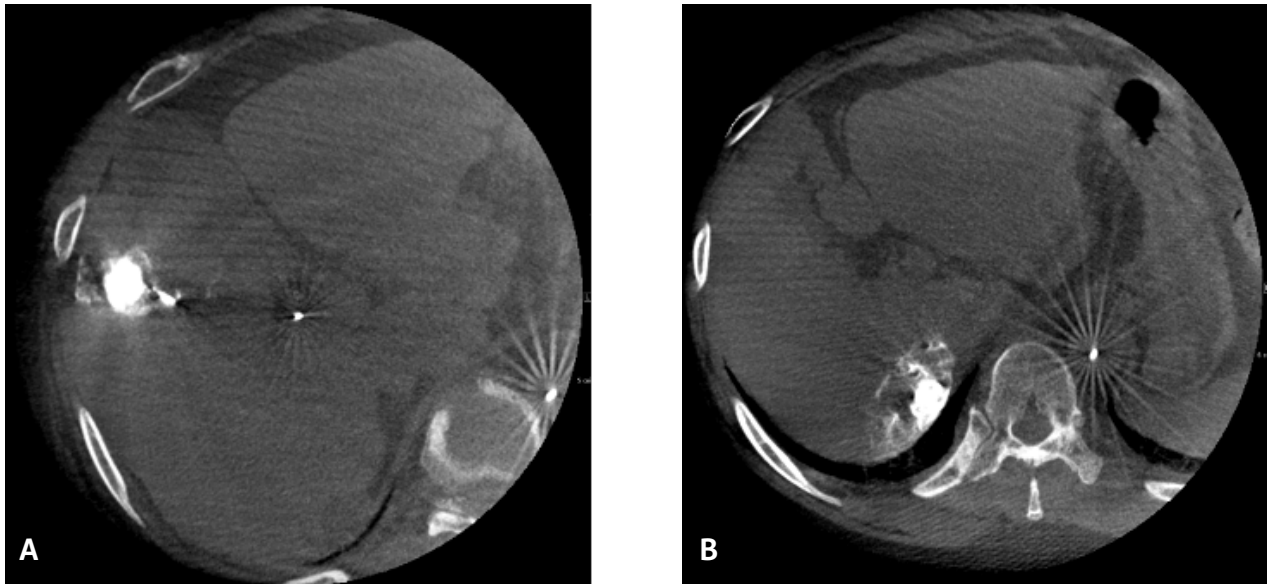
Intraoperative perfusion cone-beam CT confirms the location of microcatheter and proper supplying arteries to both (A) segment 5 and (B) segment 7 lesions.
